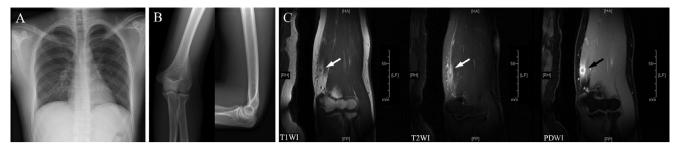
Chest X-ray revealed a cord lesion in the middle part of the left lung. (B) X-ray shows normal left elbow joint. (C) MRI of the left elbow. MRI sequences in the coronal plane revealed multiple rounded abnormal signals with irregular margins on the left distal humerus and the proximal ulnar. Lesions on images were evident (highlighted by an arrow). Proton–density-weighted images showed hyperintense lesions with annular enhancement. Proton–density-weighted images = PDWI, T1-weighted MRI = T1WI, T2-weighted MRI = T2WI.
